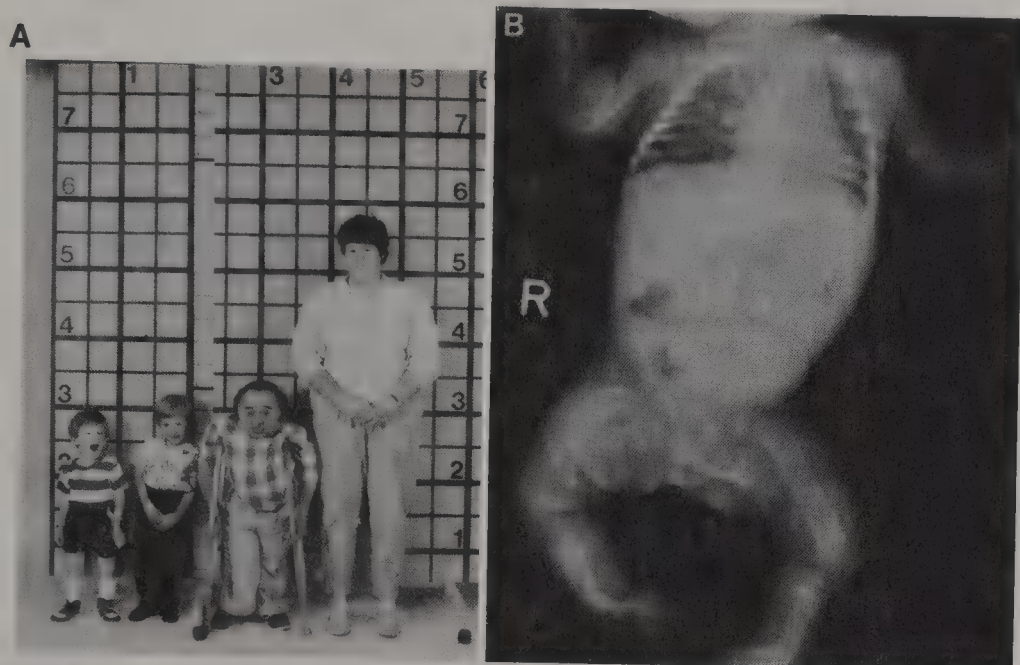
Cases of OI with unexpected inheritance. A, man with progressive deforming OI and his normal spouse have two sons, ages 4 and 7 years old, with type IV-like OI. B, radiograph of 5-month-old child with severe OI. Her father is affected with progressive deforming OI and had a sibling who died from OI in infancy.
